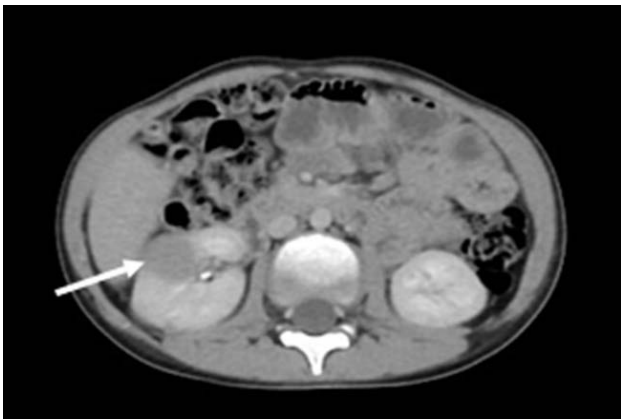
CT with contrast showing unilateral non-enhancing well demarcated focal lesion in anterior lip of right kidney
